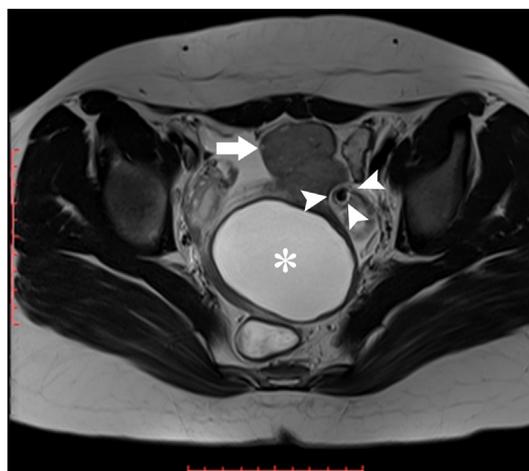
A 30-year-old woman with left ovarian torsion due to ovarian cyst (asterisk). The arrow indicates enlarged left ovary with peripherally located cysts. A twisted ovarian pedicle and the whirlpool sign are present adjacent to the torsed ovary. At the center of the “whirlpool sign”, a “T2-hypointense dot sign” (arrowheads) is present as a hypointense dot on the T2-weighted image.
